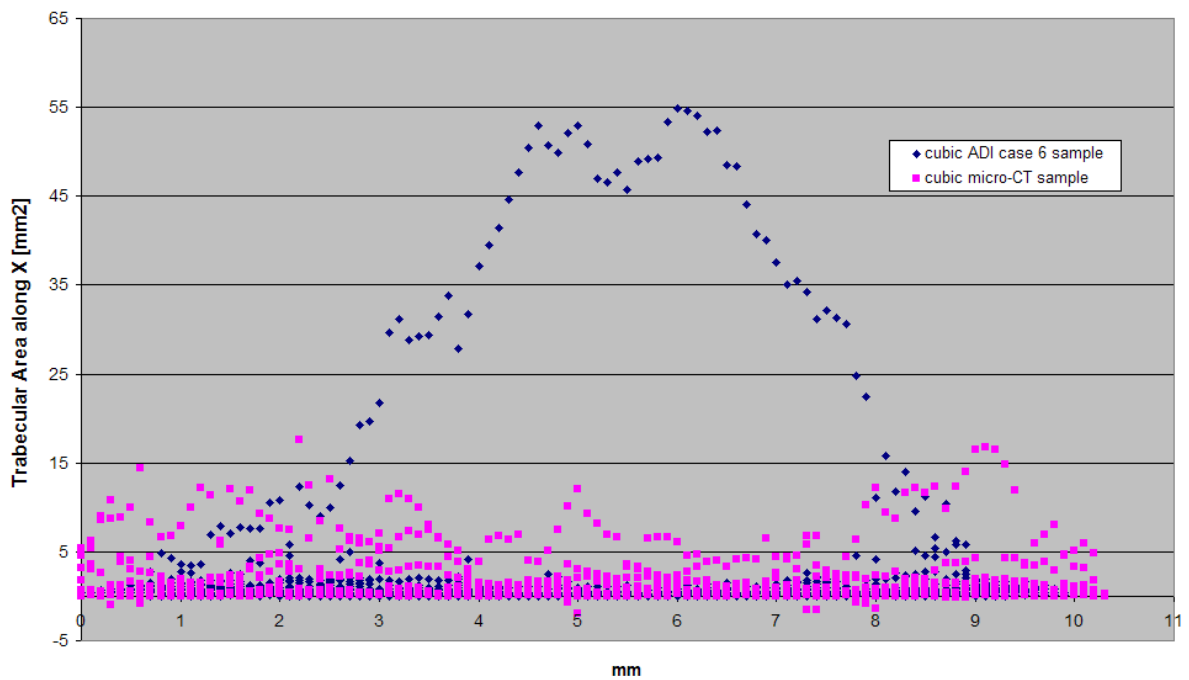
Comparison of sliced area along *X* between the cubic ADI case 6 sample and cubic  $\mu$ CT sample
